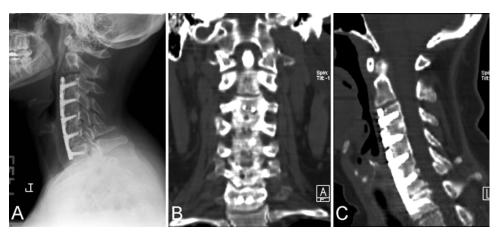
Radiographs obtained 1 year postoperatively in a patient who underwent a 4-level ACDF procedure. A: Lateral radiograph demonstrating a 4-level ACDF with possible pseudarthrosis at C6–7. B and C: Coronal (B) and sagittal (C) CT reconstructions confirming the pseudarthrosis at C6–7.
